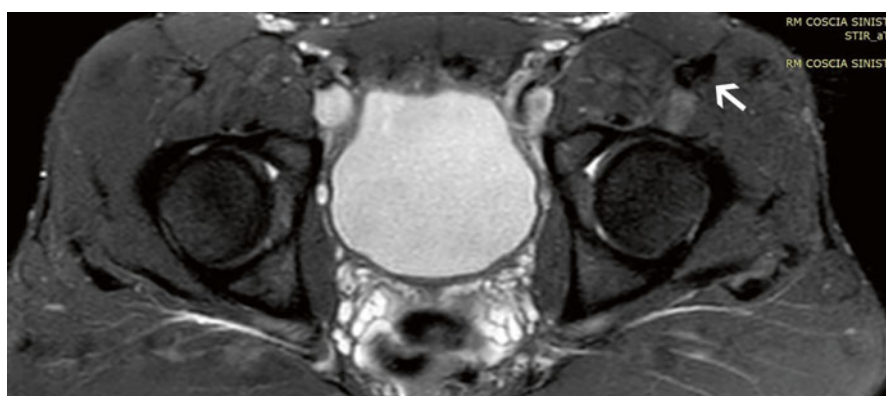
Axial STIR MRI view of the pelvis; the tendon is thicker with minimal internal changes in its structure
